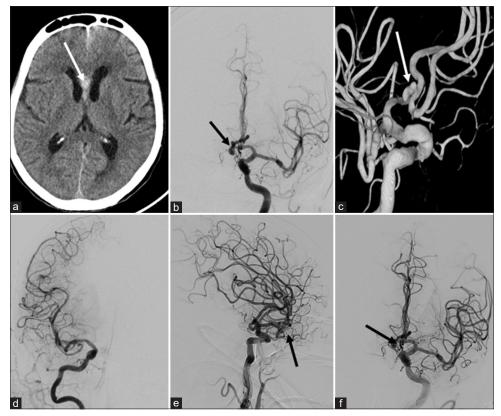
Case 1. Non-enhanced CT scan shows evidence of acute subarachnoid hemorrhage (White arrows, a). Digital subtraction angiogram AP projection (b) and 3D reconstruction of rotational angiogram (c) shows a saccular aneurysm arising from the Anterior communicating artery (Black arrow in b, White arrow in c). The right A1 segment was found to be hypoplastic (d) and both A2 segments were noted to be filling from the left side. Post-coiling check angiograms in AP projection (e) and lateral projection (f) show near-total occlusion of the aneurysm (Black arrows in e and f)
